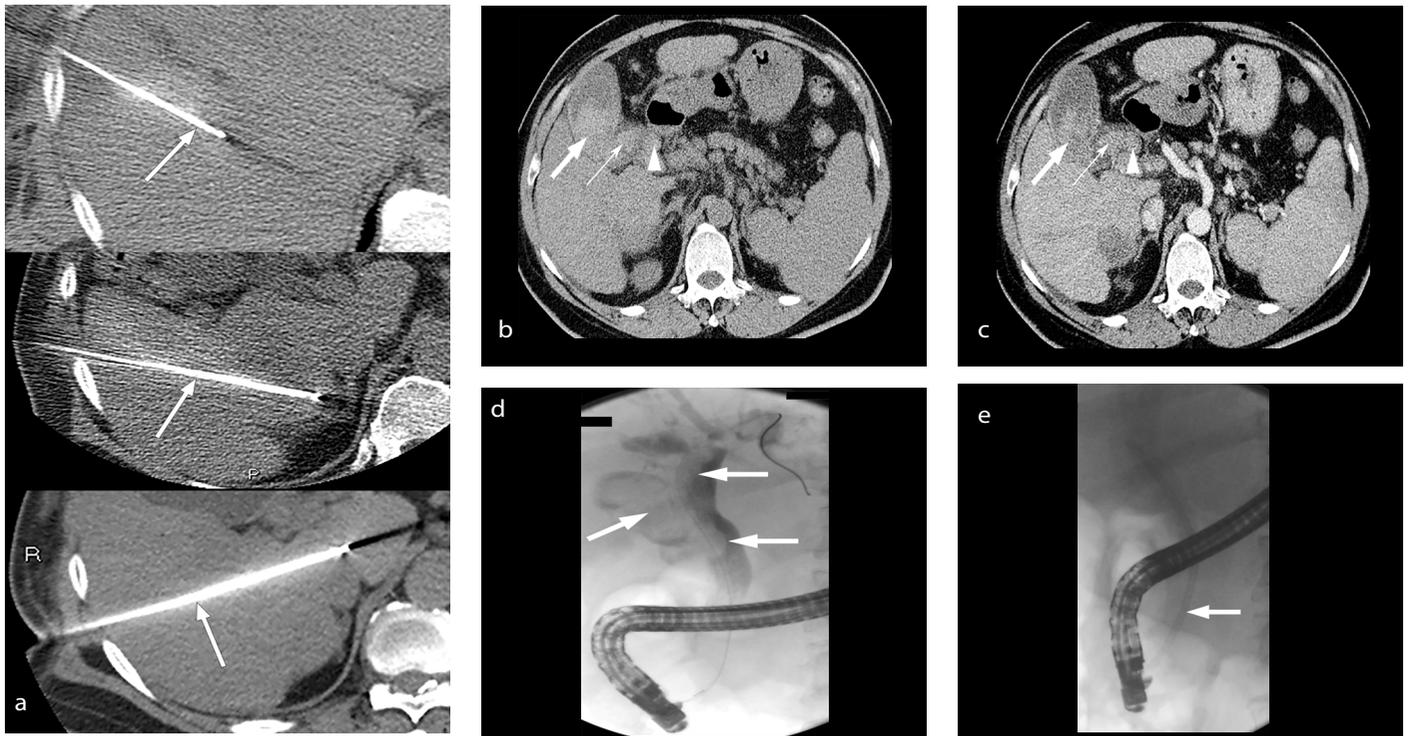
(a-e) Hemobilia presenting as melena with hemoglobin drop. The patient underwent sequential radiofrequency ablation (RFA) of three hepatocellular carcinomas in the same setting. Axial plain computed tomography (CT) images (a) show the RFA needle's position (arrows) in the segments 5/8, 5, and the caudate lobe. Axial CT (one week post ablation) images in the plain (b) and arterial (c) phases demonstrate hyperdense material within the gallbladder (thick arrow), cystic duct (thin arrow), and common bile duct (arrowhead), likely representing blood clots. No active contrast extravasation was noted on the CT scan. An endoscopic retrograde cholangiography (ERCP) was performed since the serum bilirubin level was markedly elevated. Fluoroscopic spot image from the ERCP (d) shows filling defects (arrows) within the opacified common bile duct, cystic duct, and gallbladder, likely caused by blood clots. (e) A plastic biliary stent (arrow) was deployed endoscopically for drainage of the biliary system.
